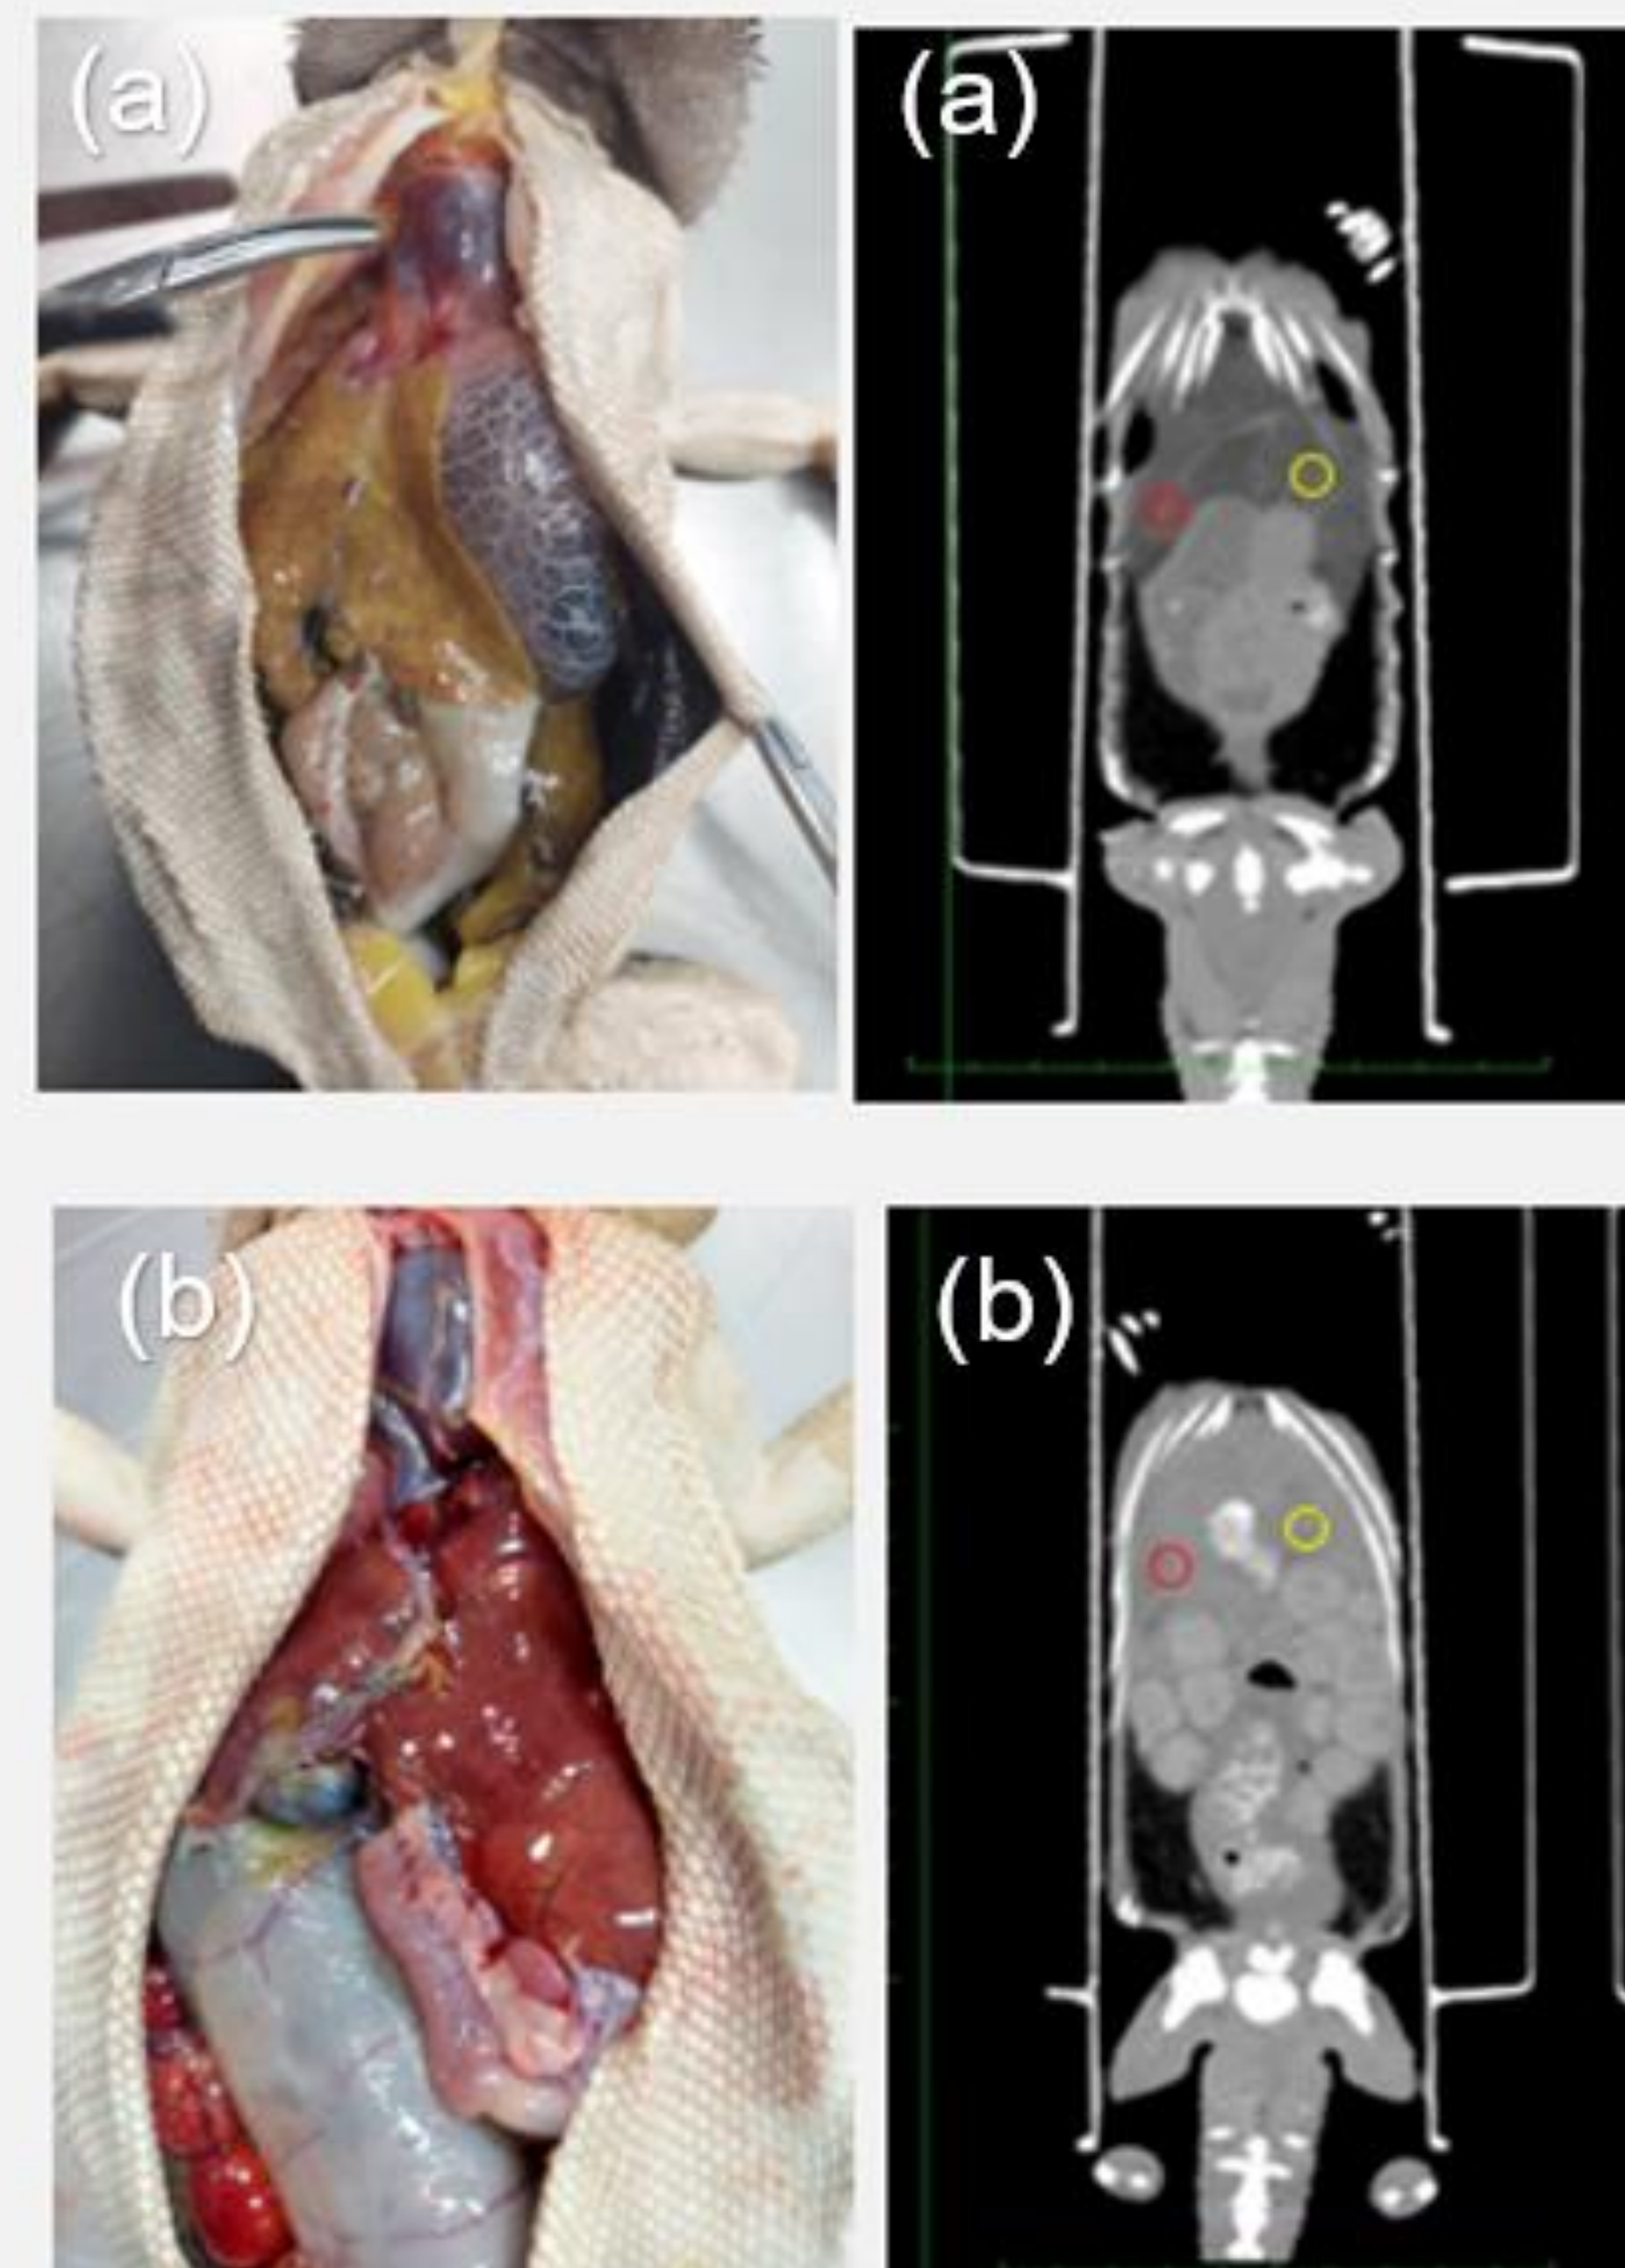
CT and necropsy images of a lipidotic (a) and normal (b) bearded dragon. Left (yellow) and right (red) lobe standard ROIs for determining liver density in HU on CT coronal views. The average between these two lobes was calculated as an estimate of the overall HU of the liver.
